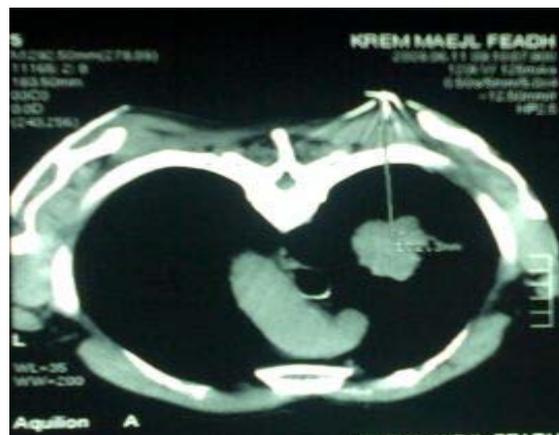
CT chest of patient with lung mass, showing the biopsy needle successfully inserted into the mass.
